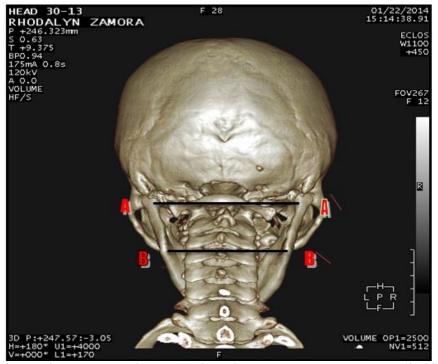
The axial posterior reconstruction three dimensional computed tomography (3D CT) image of skull showing the studied two measurements of the mandible. AA\, Bicondylar breadth; BB\, Bigonial breadth.
